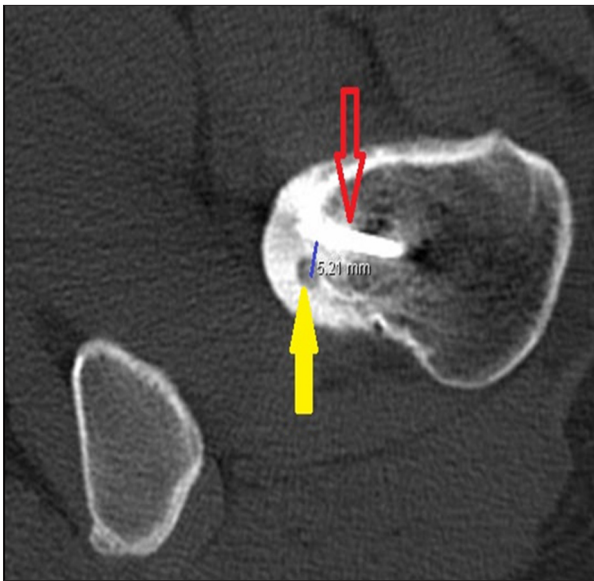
Measurement of the distance between K wire and center of nidus on axial view of CT image. Red arrow: View of K wire; Yellow arrow: View of nidus; Blue line: Distance between K wire and center of nidus.
